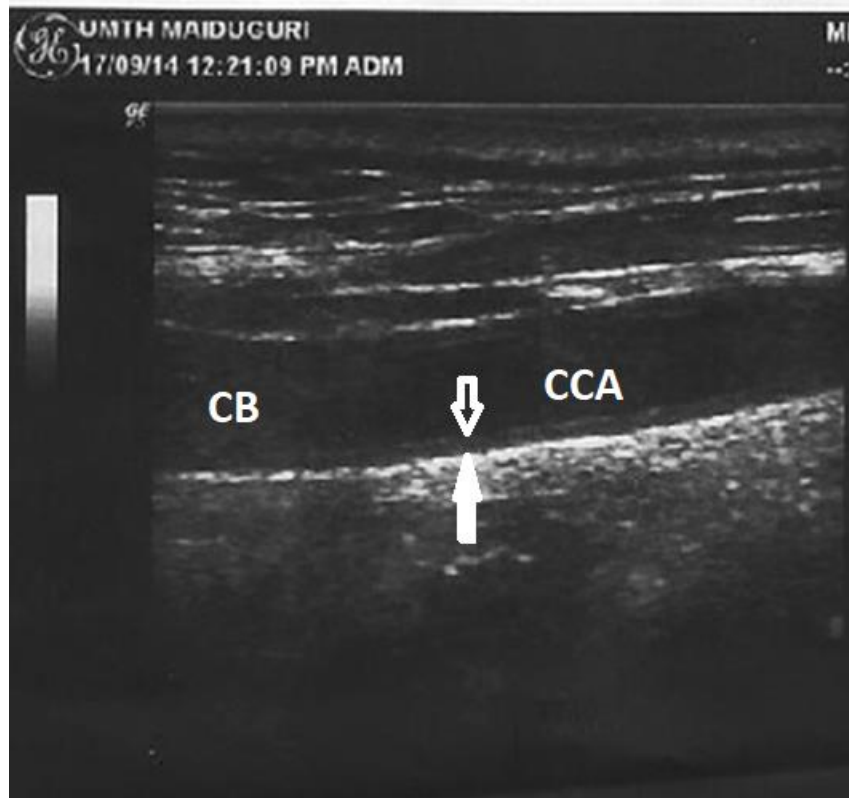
Longitudinal view ultrasound image of CCA showing measurement of IMT
